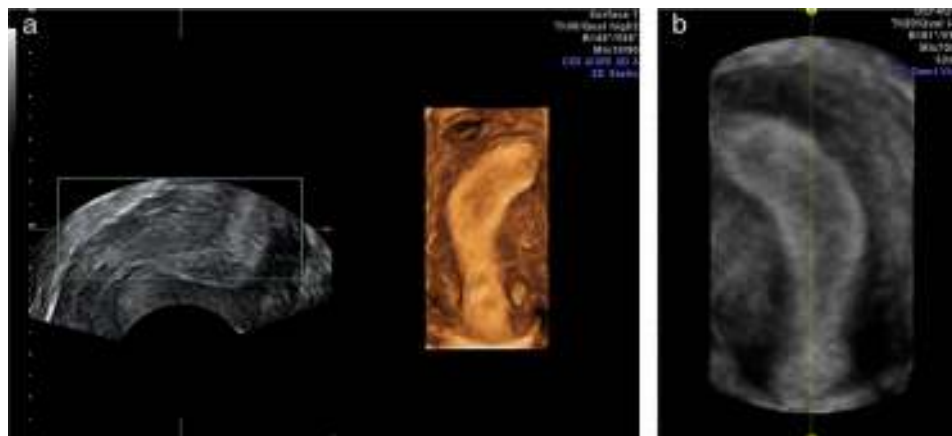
2D and 3D ultrasound view showing unicornuate uterus.
